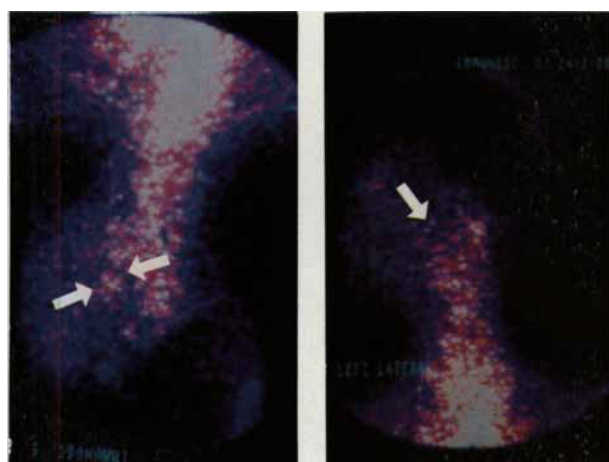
Lateral immunoscintigrams of a patient with an acinic cell carcinoma in the right parotid gland. a) Right side. b) Left side.
